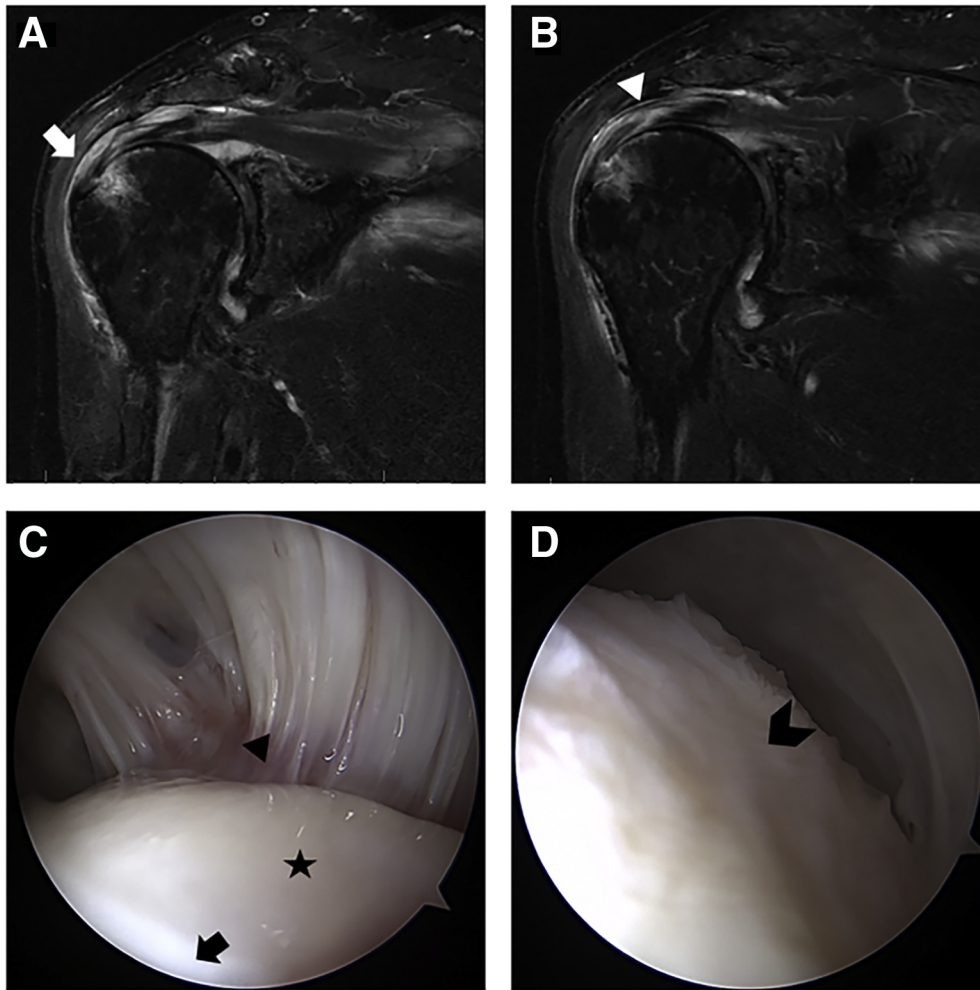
(A, B) T2-weighted coronal magnetic resonance imaging scans of a right shoulder showing increased signal intensity at the supraspinatus insertion (white arrow) and intratendinous irregularities (possible intrasubstance tear; white triangle). (C) Intra-articular arthroscopic visualization of the corresponding right humeral head (black star) and supraspinatus footprint area (black triangle) through the posterolateral portal in the lateral decubitus position from inside an air bubble (the edge of which is seen at the lower left corner; black arrow) shows the supraspinatus attachment. (D) Subacromial positioning of the arthroscope through the posterolateral portal in the lateral decubitus position confirms an intact rotator cuff (black chevron).
